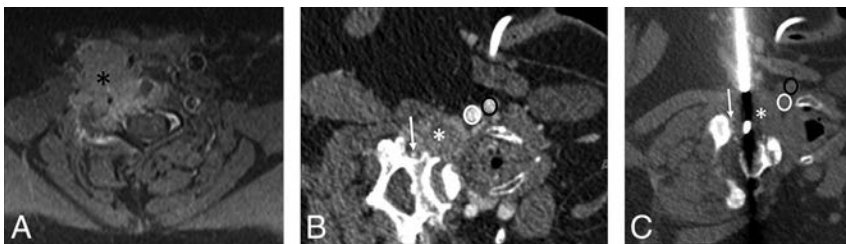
A 70-year-old woman with a history of lung cancer and a new right C5 mass extending into the adjacent soft tissues. A, Axial T1 fat-suppressed postcontrast MR image with a large right C5 mass (black asterisk) extending into the adjacent soft tissues and vertebral canal. B, Intraprocedural CT angiogram with the patient in a left lateral decubitus position shows the mass (white asterisk) and adjacent vascular structures (vertebral artery, white arrow; common carotid artery, white oval; jugular vein, black oval). C, Intraprocedural CT image with the patient in the left lateral decubitus position demonstrates the biopsy using a coaxial soft-tissue biopsy needle passing between vascular structures (vertebral artery, white arrow; common carotid artery, white oval; jugular vein, black oval) into the mass (white asterisk) using a lateral approach. The surgical pathology result was metastatic lung adenocarcinoma.
